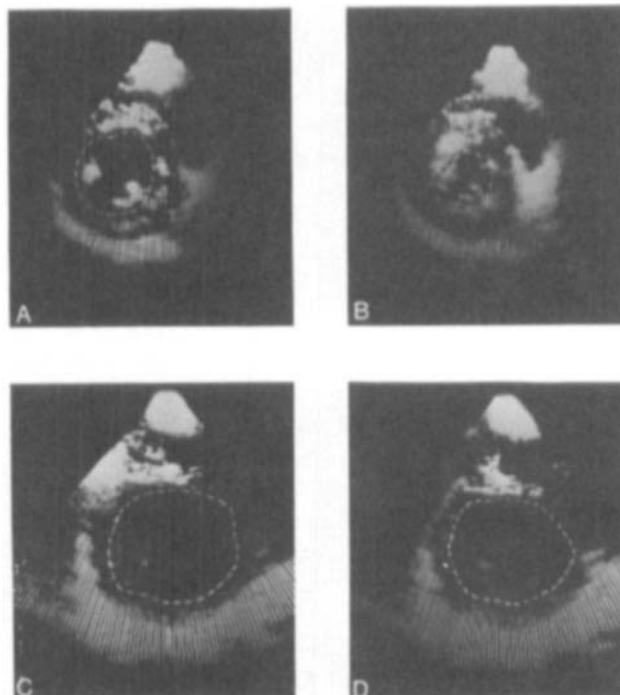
Examples of transverse echocardiographic sections at the papillary muscle level for a normal-sized and a markedly enlarged ventricle demonstrating the technique of outlining the left ventricular endocardium. A. End-diastolic image of a patient with coronary heart disease and a normal-sized ventricle (angiographic EDV = 159 ml), B. end-systolic image corresponding to A (angiographic ESV = 70 ml), C. end-diastolic image of a patient with severe congestive cardiomyopathy and a large ventricle (angiographic EDV = 393 ml), D. end-systolic image corresponding to C (angiographic ESV = 335 ml). The scale represents five centimeters along each axis.
